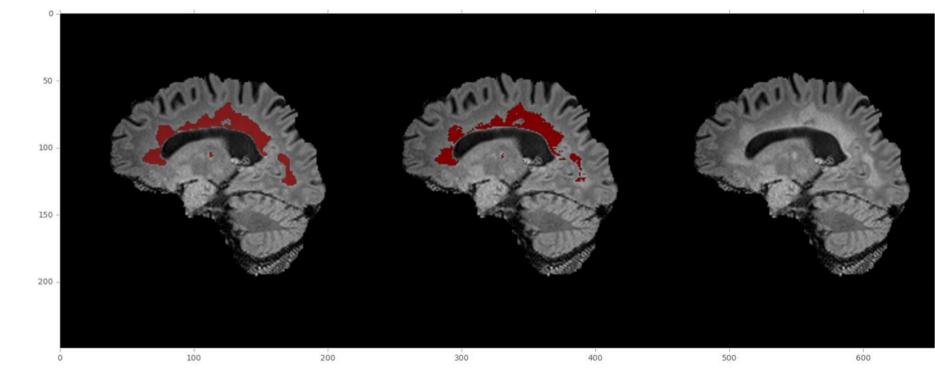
A case from the Inselspital: Right: FLAIR image. Middle: Segmentation performed by a student, in the axial direction. Left: Segmentation performed by nabla net.
